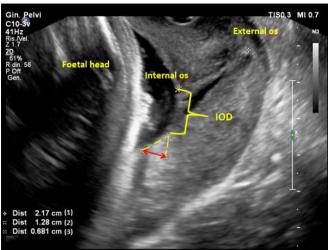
TVS evaluation of low-lying placenta. cervical length of 2.17 cm (1); IOD of 1.28 cm (2); placental edge thickness of 0.681 cm (3) shown by the red arrow; the angle between the basal and chorionic plates is identified by the yellow dotted lines. IOD, internal os distance; TVS, transvaginal sonography.
